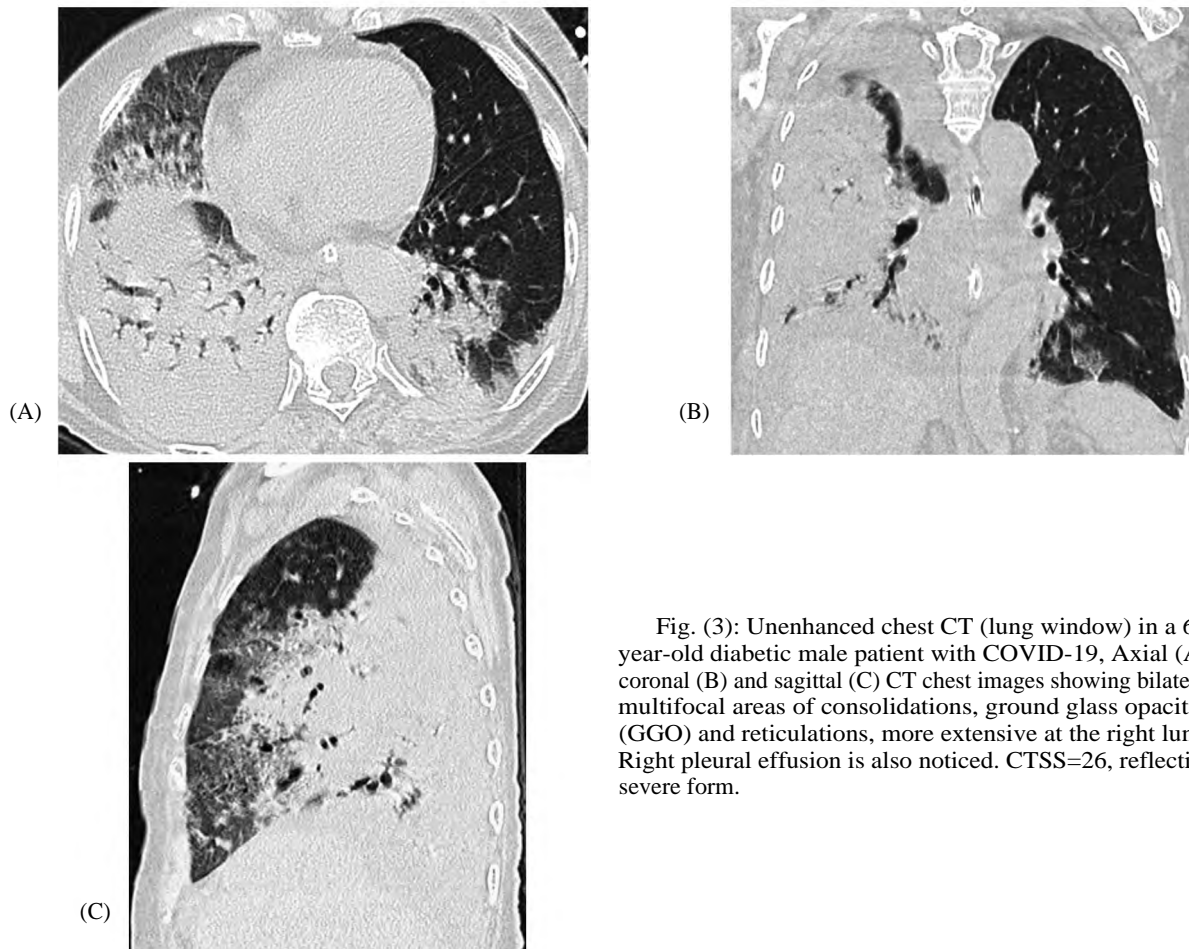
Unenhanced chest CT (lung window) in a 60-year-old diabetic male patient with COVID-19, Axial (A), coronal (B) and sagittal (C) CT chest images showing bilateral multifocal areas of consolidations, ground glass opacities (GGO) and reticulations, more extensive at the right lung. Right pleural effusion is also noticed. CTSS=26, reflecting severe form.
